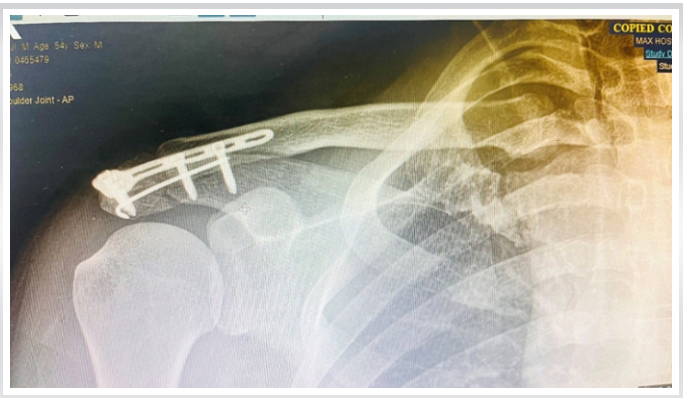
1 month post-operative X-ray
